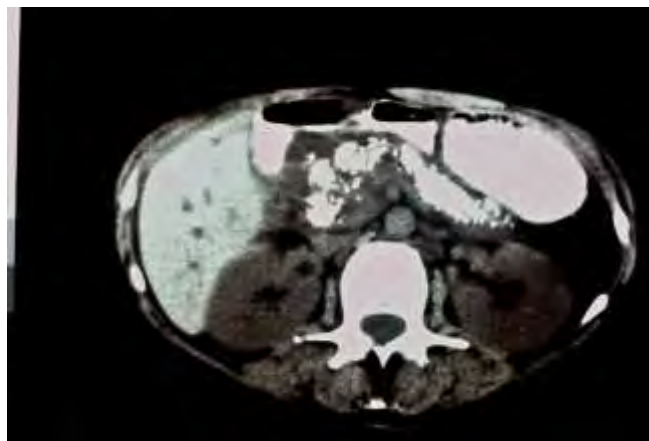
Computed tomography scan in patient SW 11 months after micronutrient antioxidant therapy. Publication details as for Figure 15.5.
